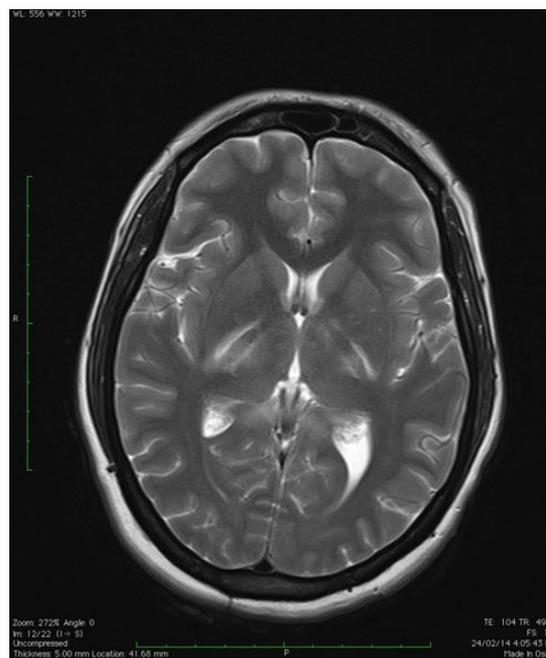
MRI showing bilateral internal capsule involvement.
